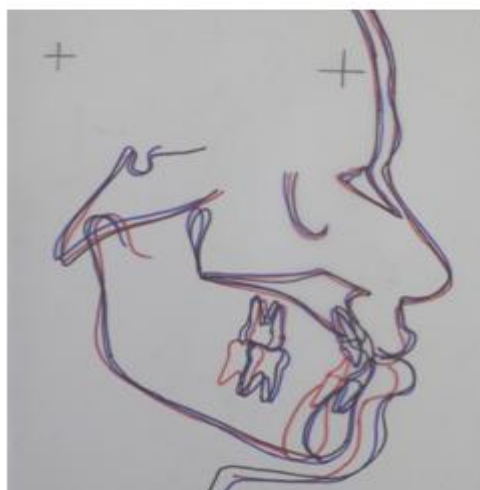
Superimposition of Pretreatment, Presurgical and Postsurgical Radiographs.
